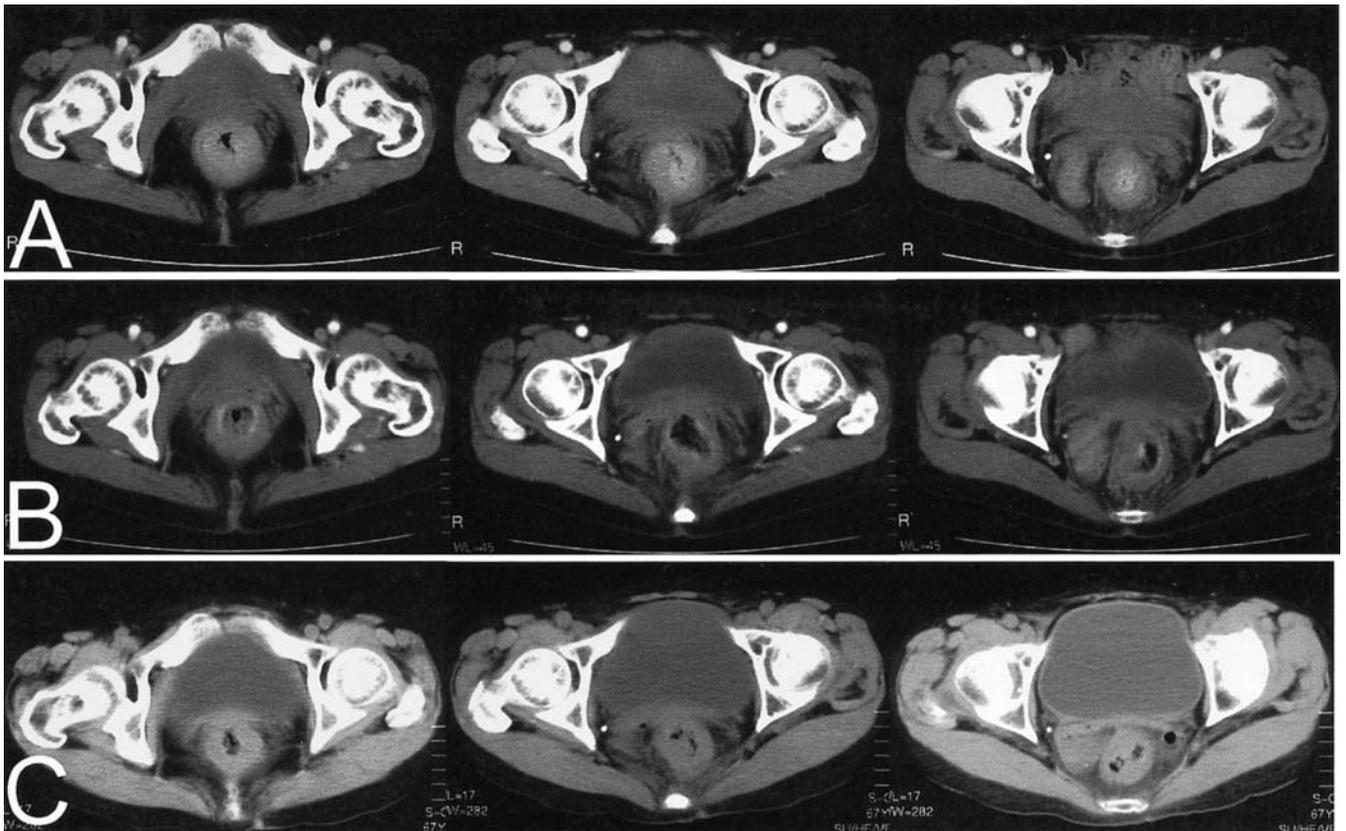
A Abdominal computed tomography (CT) scanning on admission, revealing circumferential wall thickening of the rectum, which continuously extending through the upper rectum and rectosigmoid portion. Sequential images of pelvic CT scanning B 4 months and C 8 months after the start of weekly paclitaxel, demonstrating attenuation of the extent of rectal stenosis, which was maintained for more than 10 months
